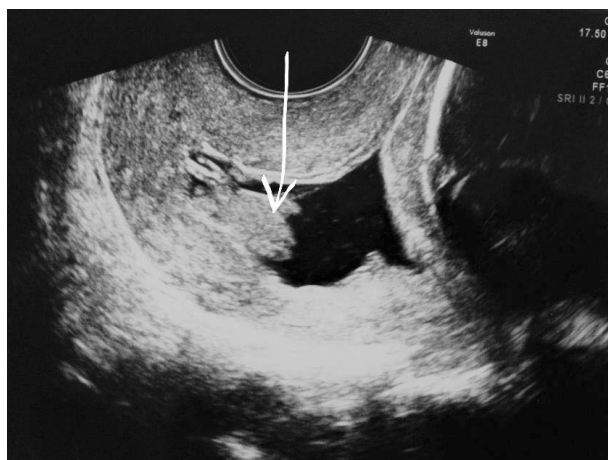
Sludge at ultrasound examination, an arrow indicating the location.
